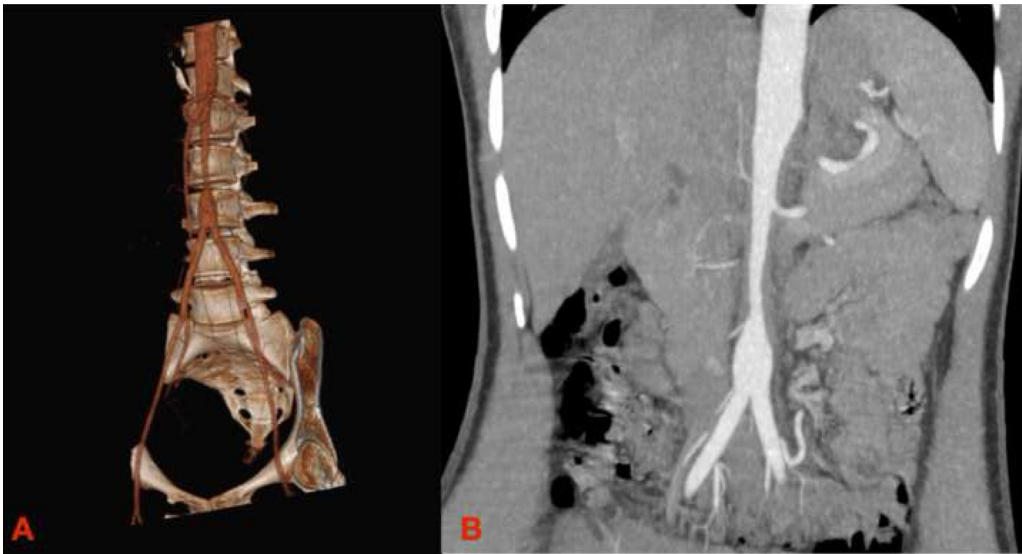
CT Angiography 3-dimensional volume rendering (A) and MPR (B) preoperative.
